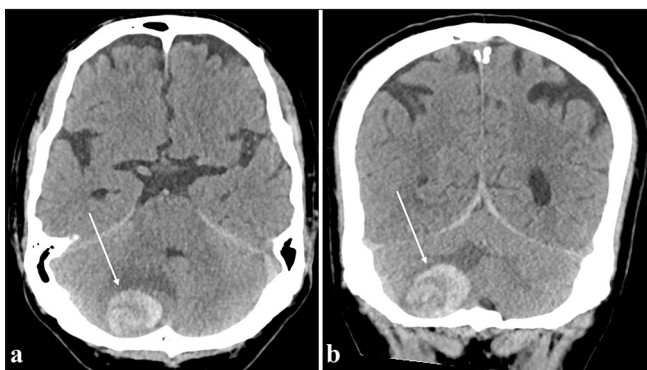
A 67-year-old male presented to the emergency department with a severe headache. (a) Axial non-enhanced computed tomography demonstrates a hyperdense hemorrhagic lesion in the right cerebellar hemisphere (white arrow), also seen on (b) coronal view (white arrow), surrounded by a moderate amount of vasogenic edema. It is associated with mass effect with effacement of the fourth ventricle and secondary dilation of the lateral ventricles.
